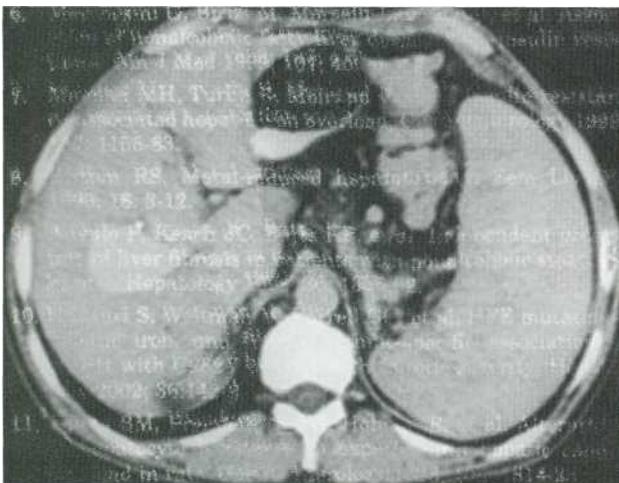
CT showing aneurysmatic malformation with tumor-like appearance
